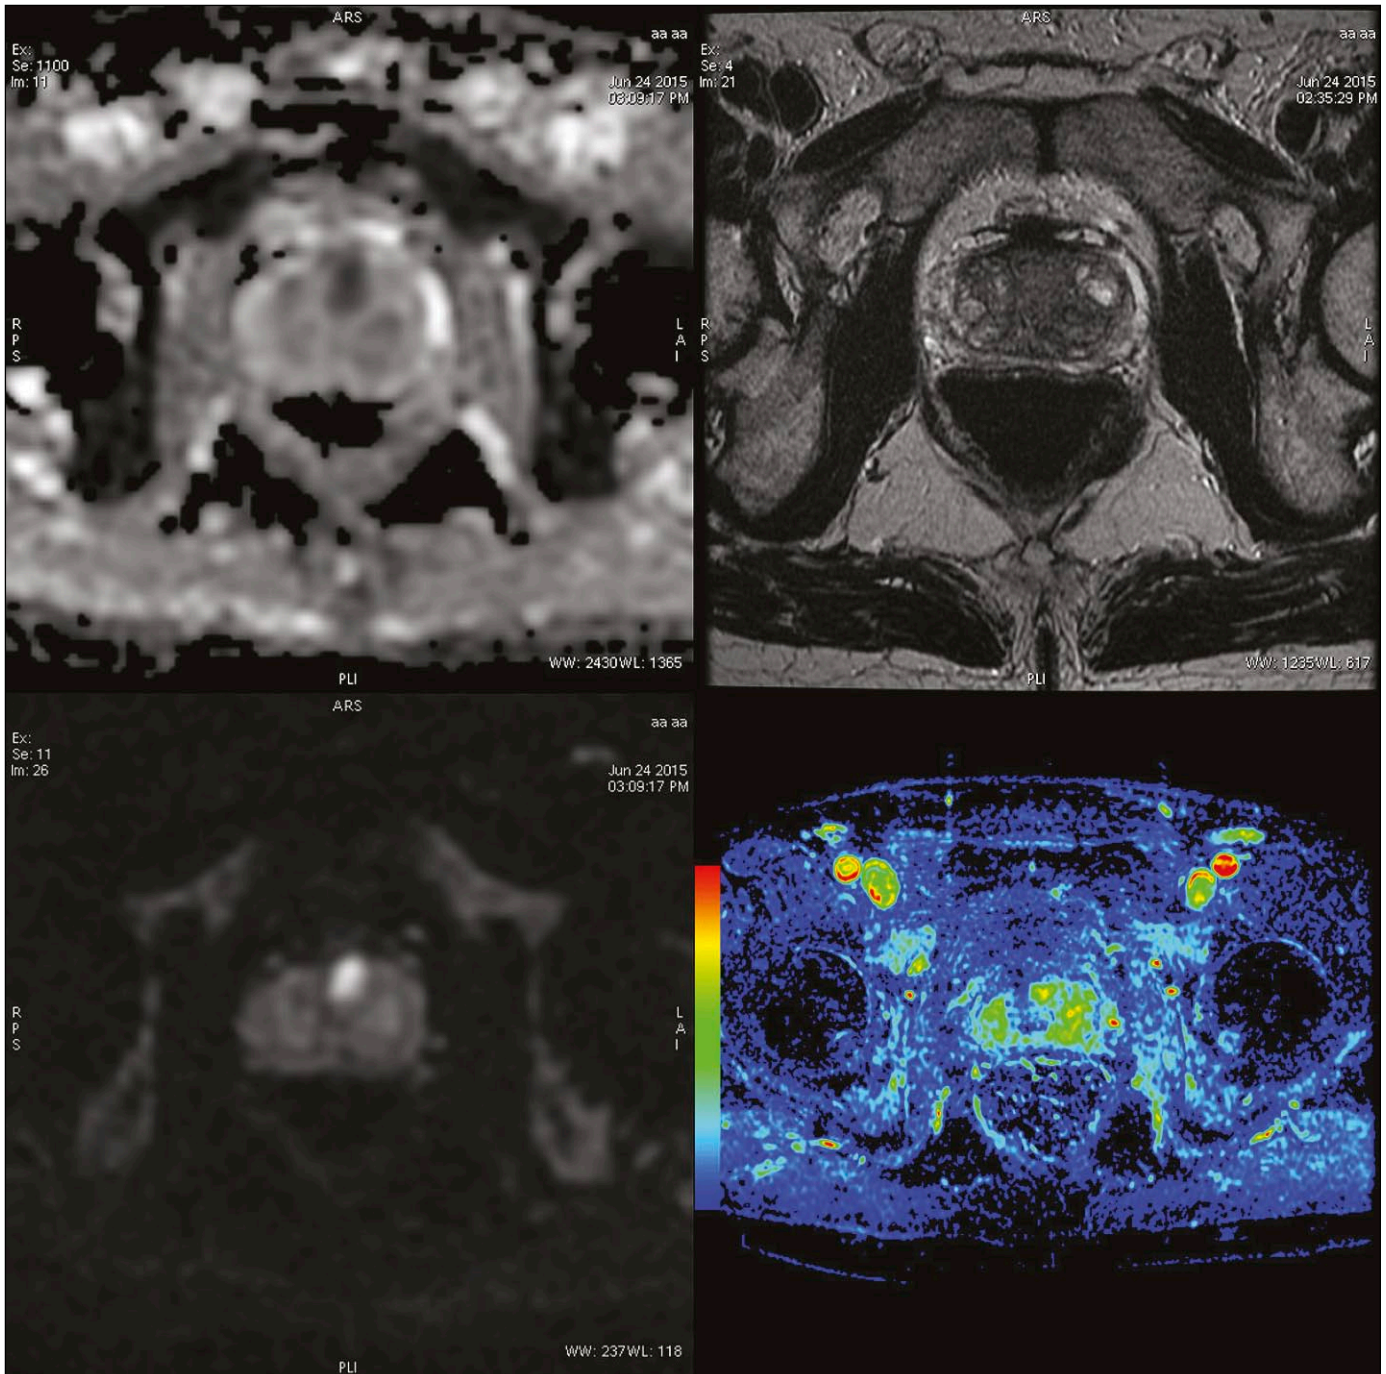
Clockwise: ADC map, T2WI, Dynamic contrast enhancement (maximum slope of increase), DWI ($b = 1400$). The set of images lets us appreciate the use of a multiparametric approach – the lesion on the border of the anterior fibromuscular stroma and transition zone is easily appreciated in DWI/ADC and DCE series, but inconspicuous on T2WI.
